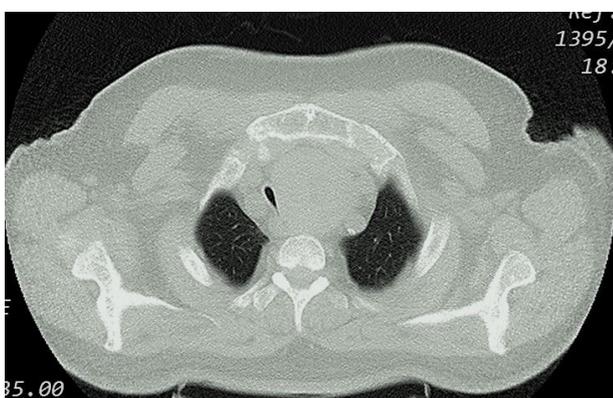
Chest CT scan of the retrosternal goiter with dyspnea (Pulmonary view)
